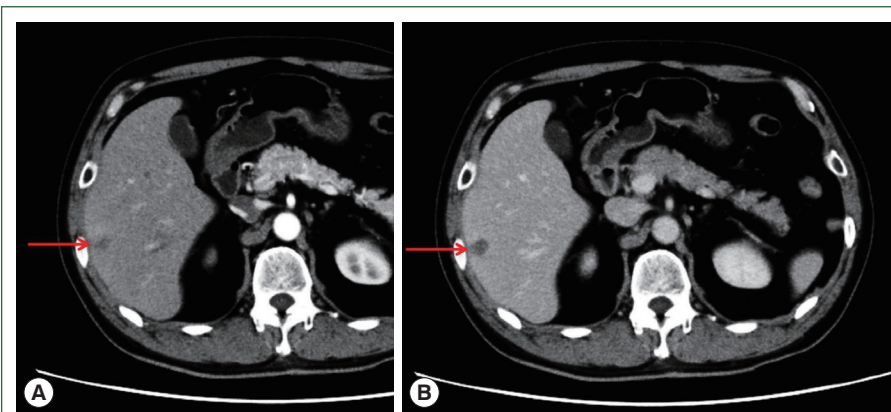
Abdominal CT. (A) Early stage of arterial phase. Contrast CT after 30 sec. (B) Equilibrium stage of arterial phase. Contrast CT after 180 sec. Arrows show a low-density area of 20 mm in size in segment 6 of the liver. CT, computed tomography.
